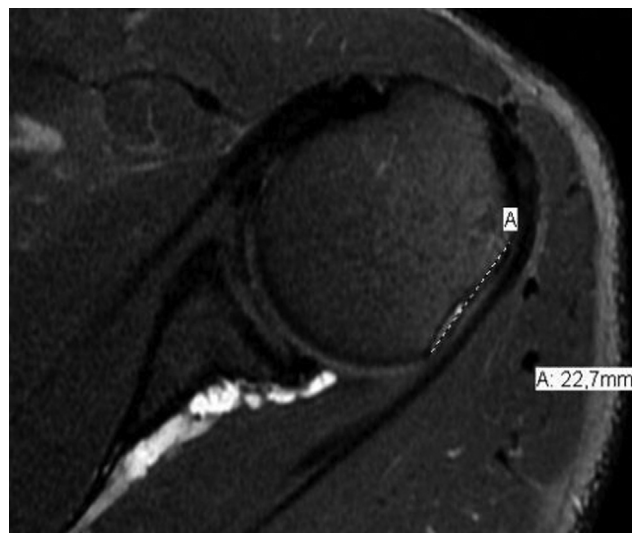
Axial slice of magnetic resonance imaging for evaluation of the Hill-Sachs interval (A).
